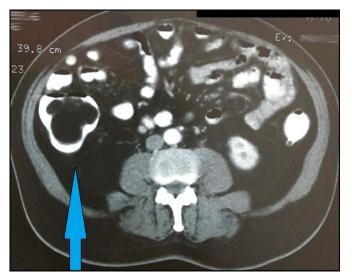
Abdominal computed tomography with intravenous and oral contrast showing a 12×5.4 cm homogenous low-density lipoma at the right colon.
